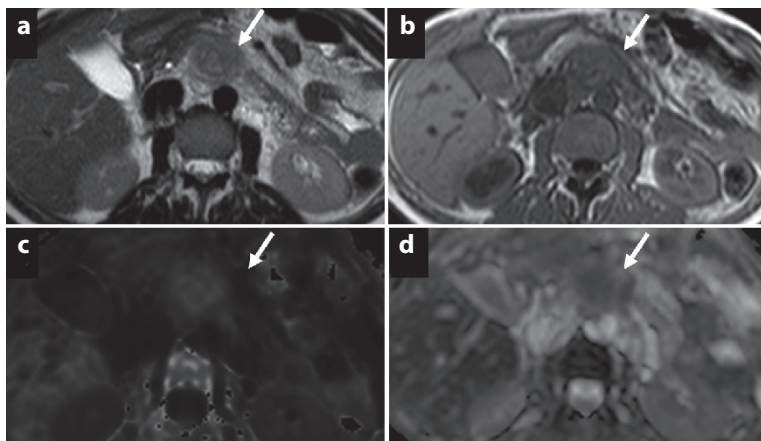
A 54-year-old man with NET of the jejunum. A rounded mass (*arrow*) of around 30 mm located within the mesentery, showing a mildly hyperintense signal on the axial T2-weighted image (a), appears hypointense on the axial T1-weighted image (b); the lesion shows appreciable restriction (*arrows*) on diffusion-weighted imaging (c) and appears hypointense on the ADC map (d)
